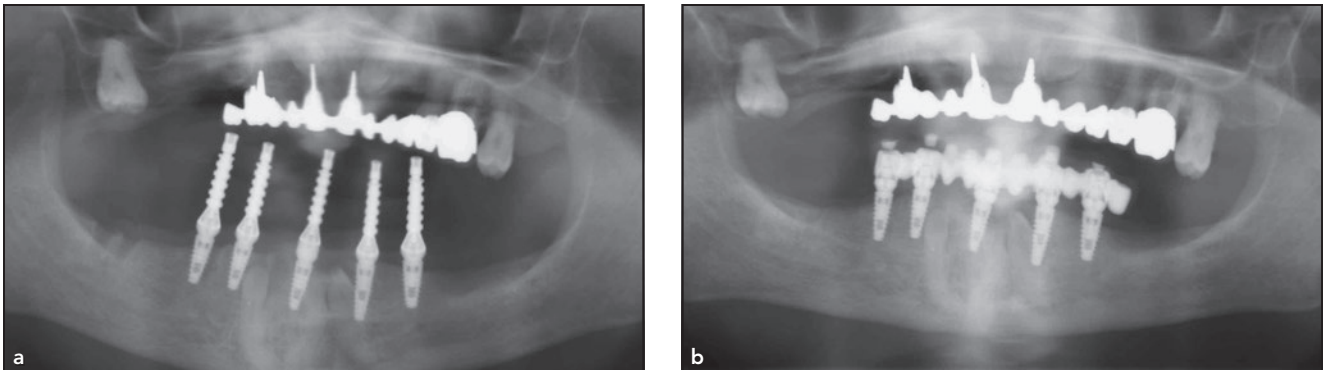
Case 3. Panoramic radiographs taken at (a) baseline and (b) the 6-year follow-up.
